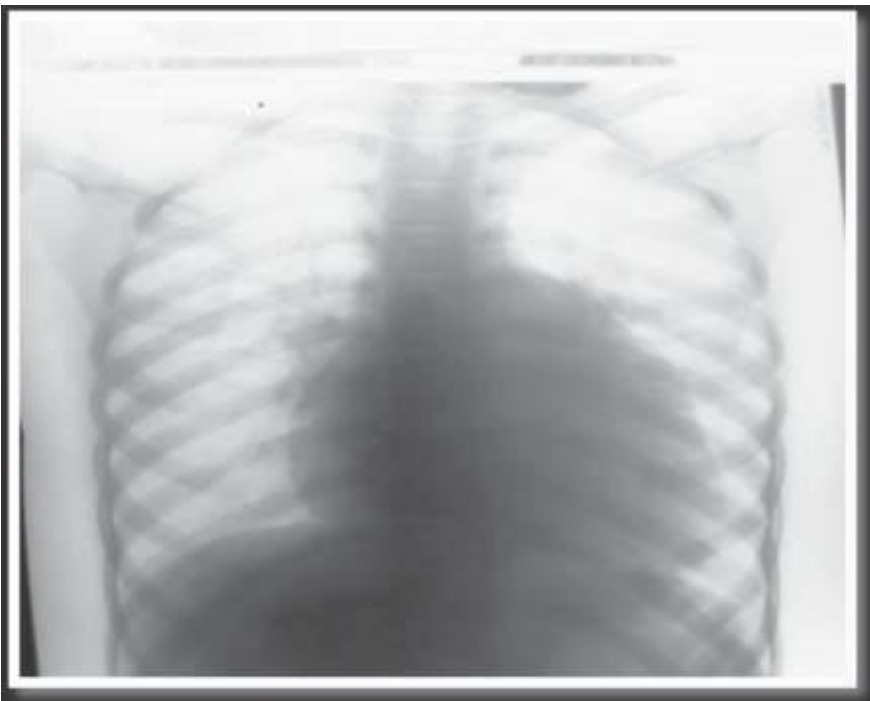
Cardiomegaly with cardio thoracic ratio 63% a with prominent pulmonum segment, the enlargement left atrial appendage visible on the left cardiac border, wide left cardiac border, descent apex. and increasing pulmonary vascular markings in chest X-ray was taken at the first admission.
